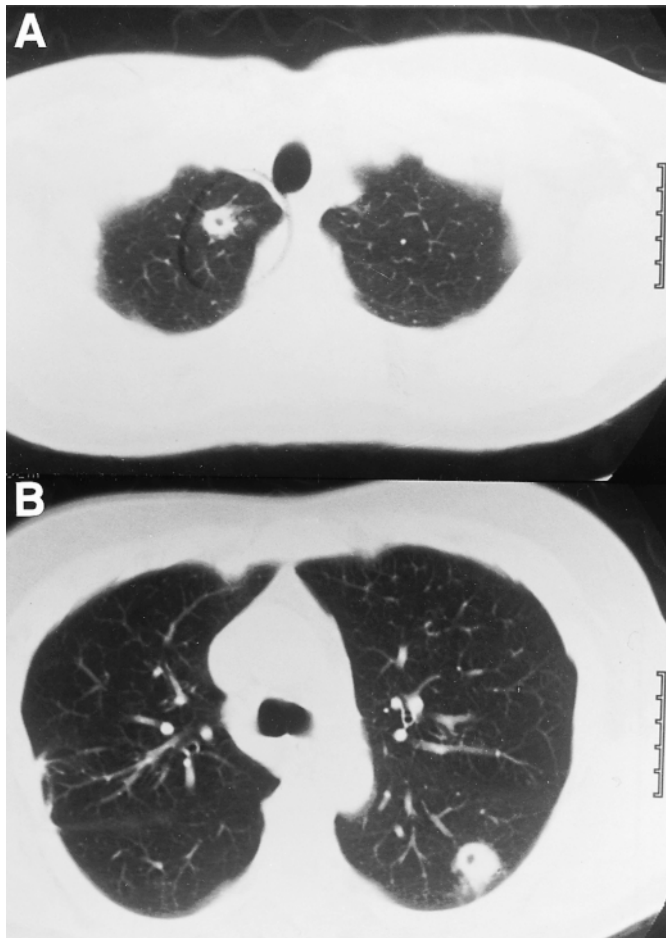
Conventional CT scan demonstrating the two largest nodules, each with small central cavitation; one in the apical segment of the right upper lobe (A) and one in the superior segment of the left lower lobe (B).
